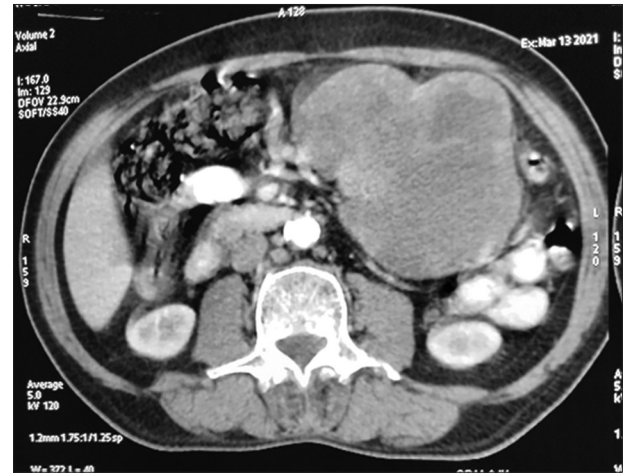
Computed tomography image showing a large exophytic heterogeneously enhancing mass lesion arising from the greater curvature of stomach with small intraluminal component measuring approximately 12.6 cm × 9.5 cm × 11.2 cm displacing adjacent bowel loops
